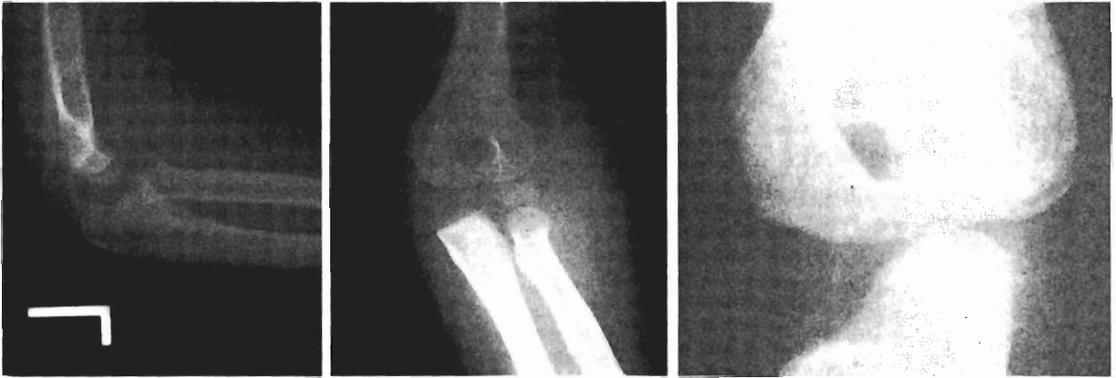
The elbow was swollen and painful; anteroposterior and lateral radiographs showed no fracture. But the oblique film disclosed a fracture of the lateral condyle.
